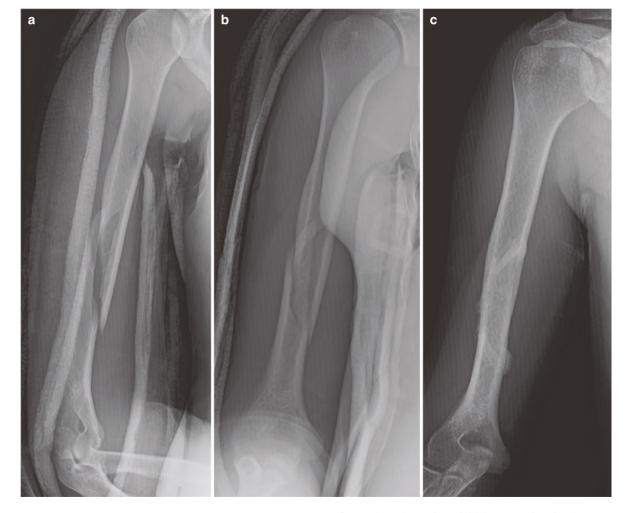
(a–d) Radiographs of a 25 year old male who sustained a mid to distal third spiral humeral shaft fracture while throwing a baseball at initial presentation (a, b) and after 10 weeks of conservative treatment (c, d). (e–j) Images of a 16 year old male who sustained a distal humeral fracture after landing on his arm during a lacrosse game.
